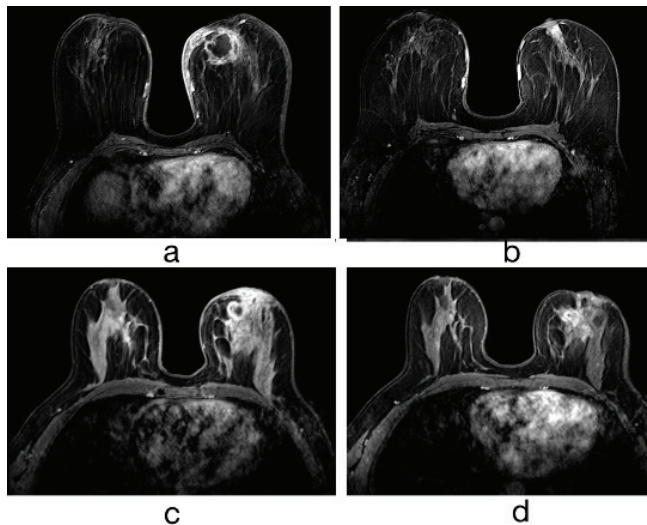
a. Patient with IGM at 36 years old. Abscess formation of 42 mm with enhancement at the wall, on medial site of left breast. b. MRI findings of the same patient on the third month following the end of combined steroid treatment. Abscess formation and the thickness of skin have disappeared. The complete radiological response was observed. There was no recurrence with the follow-up of 42 months. c. Patient with IGM at 37 years old. Retroareolar abscess formation of 20 mm with peripheral enhancement, at left. d. Partial radiological response was observed following systemic steroid therapy for 4 months. Recurrence was observed on the fifth month of follow-up with a palpable mass with pain, and the patient underwent surgery
